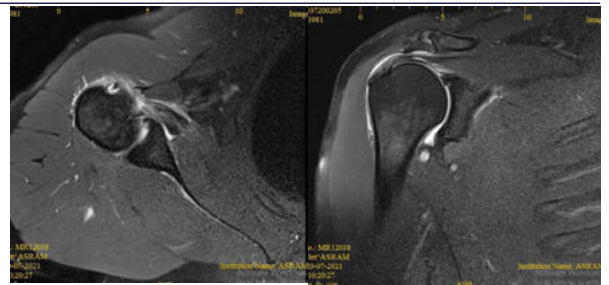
MRI axial and coronal PD fat sat. images of shoulder showing biceps long head tendon tenosynovitis, partial thickness tear of subscapularis and intrasubstance supraspinatus tear.
